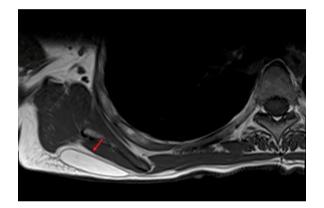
Normal fat tissue intervenes between the tumor and the underlying structures. Axial T1-weighted MRI shows a lipoma of the left shoulder. Normal fat tissue lies between the lipoma and the underlying structures (red arrow)
